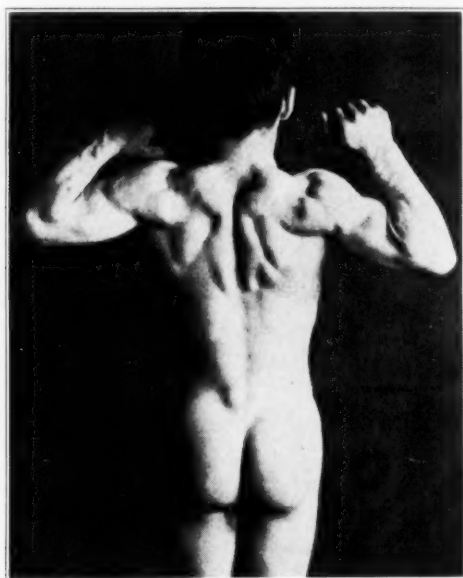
Photograph of the patient before operation or roentgen treatment, showing the high degree of muscular development.
